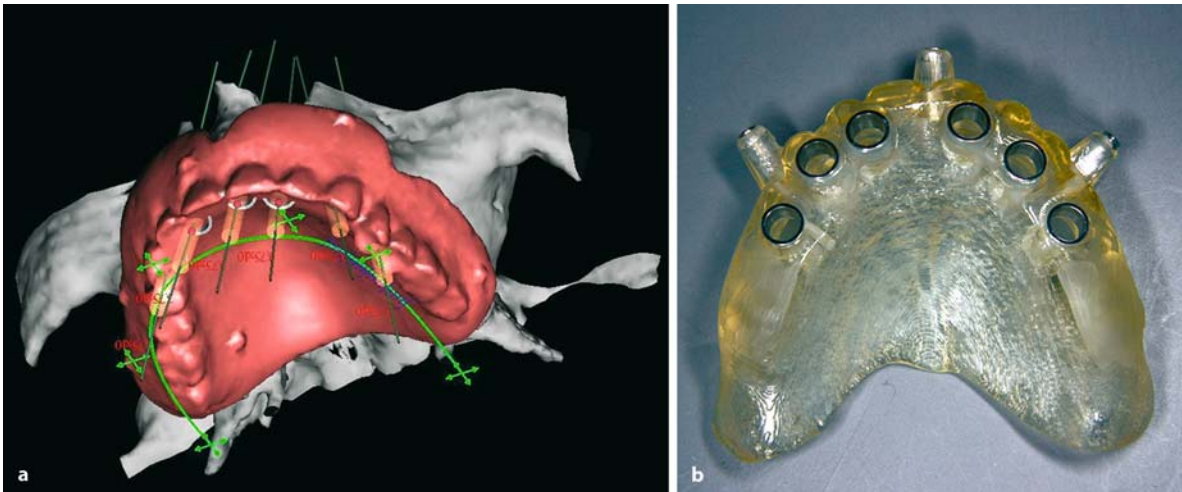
a,b. Implant insertions with CAD-CAM drilling templates. The CT-based planning of implant position forms the basis for fabricating the drilling template. The template is attached
